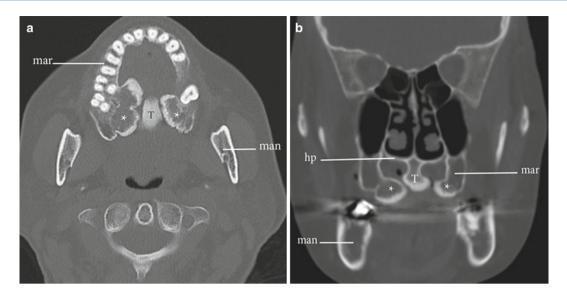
Tori maxillaris and palatinus. Axial (a) and coronal (b) CT images with bone windows demonstrate exostoses projecting from the maxilla (*asterisk*) and hard palate (torus palatinus, T). Maxillary alveolar ridge (*mar*, a, b), mandible (*man*, a, b), hard palate (hp, b)
